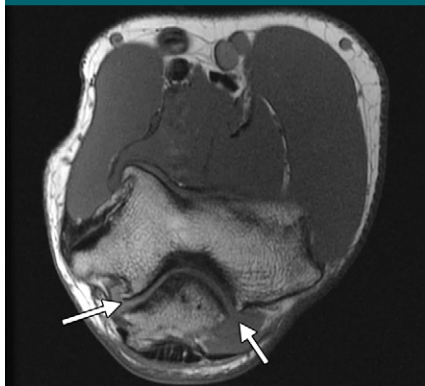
Coronal T1-weighted MR arthrographic image in a 22-year-old female gymnast with prior UCL reconstruction demonstrates an intact graft (arrows).
